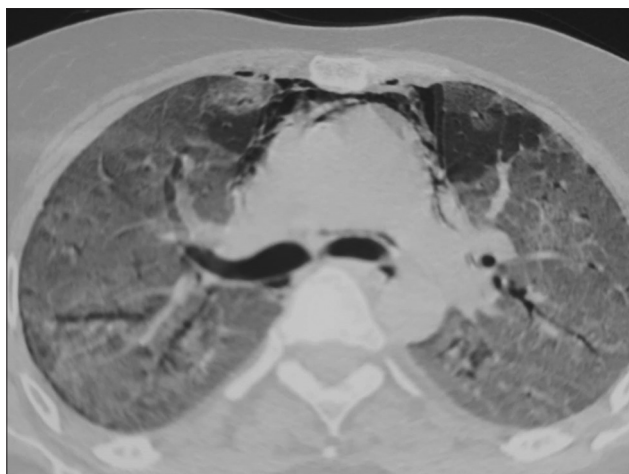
HRCT thorax of patient revealing bilateral ground glassing with pneumomediastinum and pneumothorax
